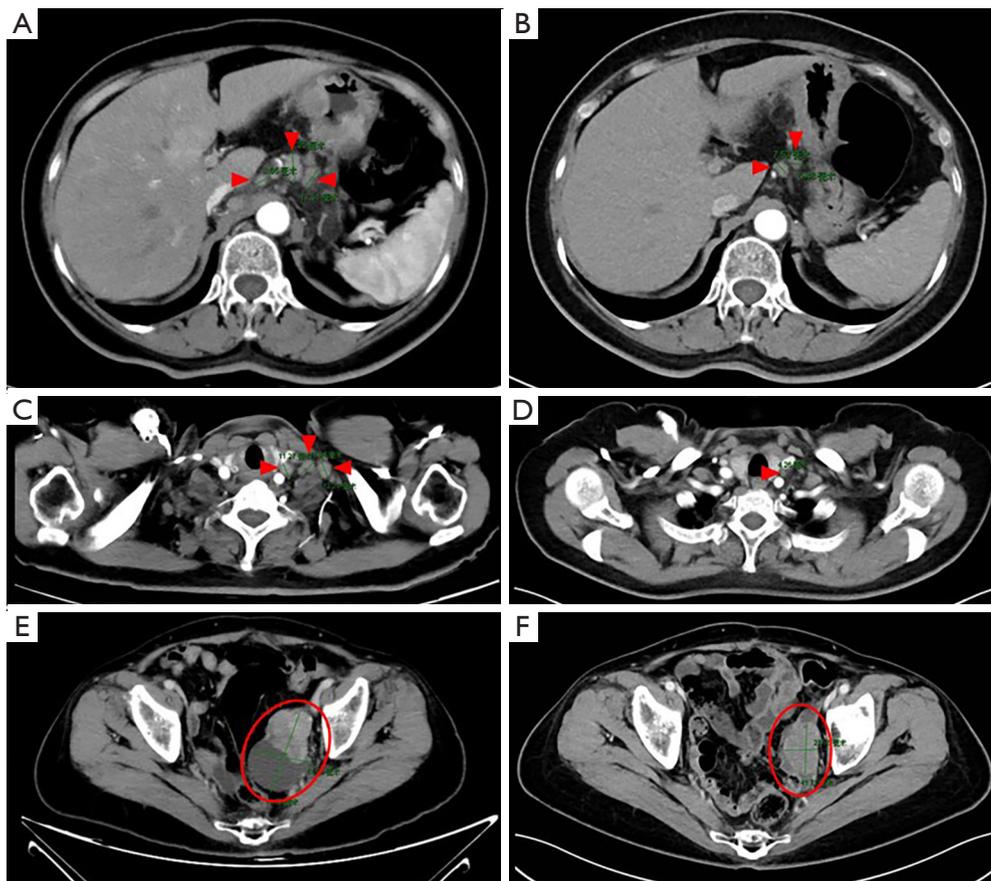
CT images of patient #3 before and after treatment of combination regimens. (A) The paraaortic lymph nodes were marked by red arrow heads before treatment and the longest diameter of lymph nodes was 17.25, 8.05, and 12.31 mm, respectively; (B) after three cycles of combination treatment, the sizes of paraaortic lymph nodes marked by red arrow heads reduced to 7.52 mm, 6.48 mm, and unmeasurable; (C) the left supraclavicular lymph nodes were marked by red arrow heads before treatment and the longest diameter of lymph nodes was 11.27, 13.04, 12.21 mm, respectively; (D) after three cycles of combination treatment, the sizes of left supraclavicular lymph nodes marked by red arrow head reduced to 4.26 mm and unmeasurable. The left ovarian metastatic tumor marked by red ellipse circle shrank dramatically from 74.32 mm × 51.95 mm (E) to 41.71 mm × 27.96 mm (F) after 3 cycles of treatment. CT, computed tomography.
